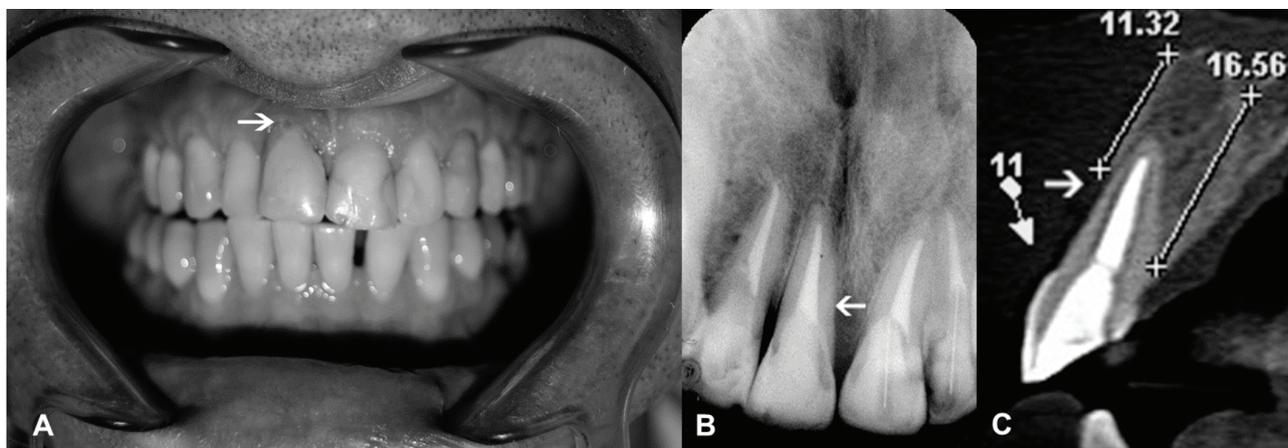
A: clinical, B: radiographic and C: tomographic diagnosis of bone loss due to periodontal disease and traumatic mobility of the right upper incisor
